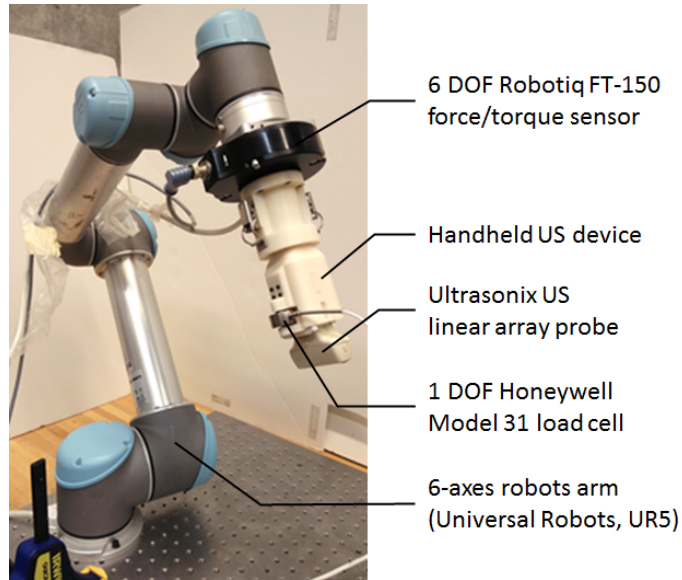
The co-robotic ultrasound system with dual force sensing. The US probe is actuated by a 6-axis robotic arm through the users force input on the handheld device.
